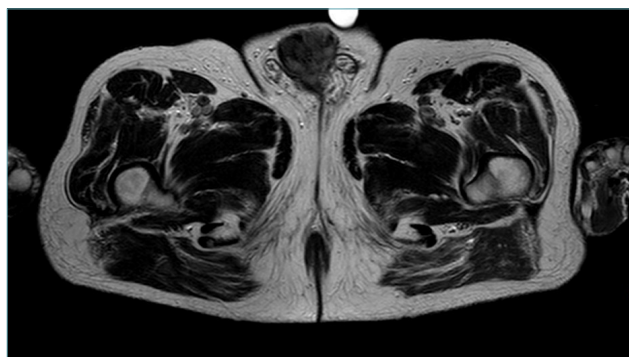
Dedifferentiated liposarcoma: CT scan showing a 4-cm lesion at the root of the penis infiltrating the surrounding tissues.
